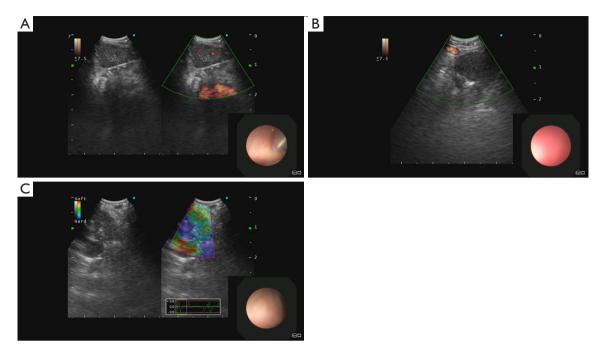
Advanced EBUS techniques: EBUS-TBNA, blood flow Doppler, and elastography. (A) Dual screen view of EBUS 2D mode (left) and corresponding color Doppler mode (right) of lymph node and vessel. (B) Color Doppler mode EBUS view of lymph node and adjacent vessel. (C) Dual screen view of EBUS 2D mode (left) and corresponding elastography mode (right) of lymph node. EBUS, endobronchial ultrasound; TBNA, transbronchial needle aspiration; 2D, two dimensional.
